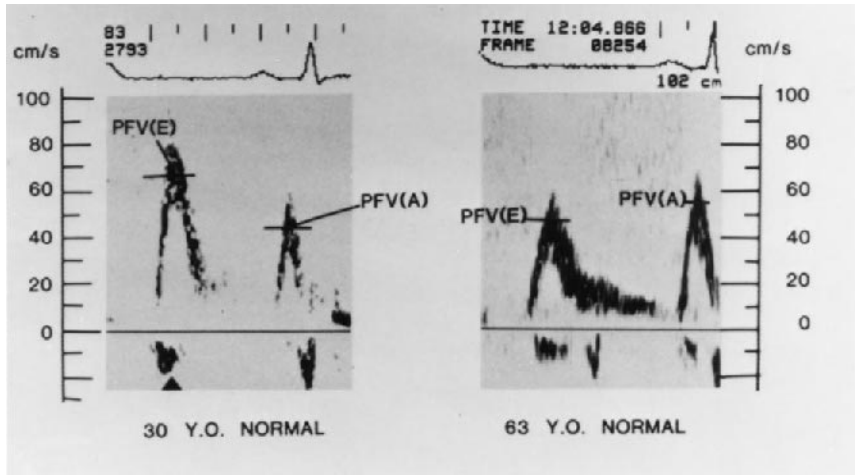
Doppler mitral valve flow velocity recordings from a younger normal subject, age 30 (left), and from an older normal subject, age 63 (right). Note that the peak flow velocity at early diastole in the older subject is lower and the late diastolic peak flow velocity is higher than in the younger normal subject. (Reprinted from Ref. 25, with permission.)
